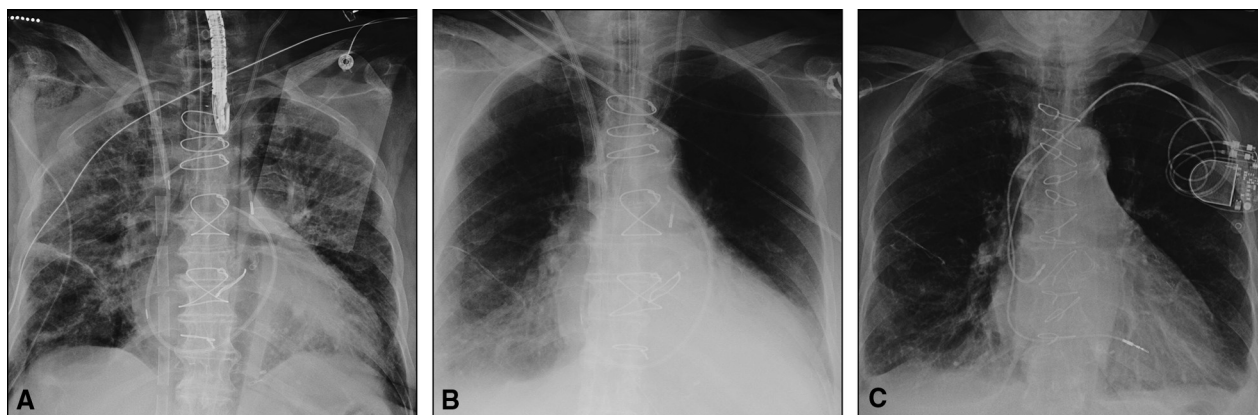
A, Chest radiograph after extracorporeal membrane oxygenation institution. B, Resolving pulmonary edema on extracorporeal membrane oxygenation support can be seen on the chest radiograph before aortic valve replacement. C, Chest radiograph before discharge from the hospital.
